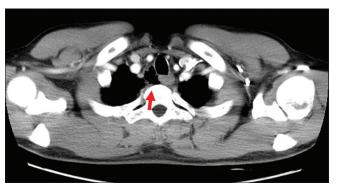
CT of the chest in December 2010 showed mild progression of the right upper paratracheal free air. CT: Computed tomography
